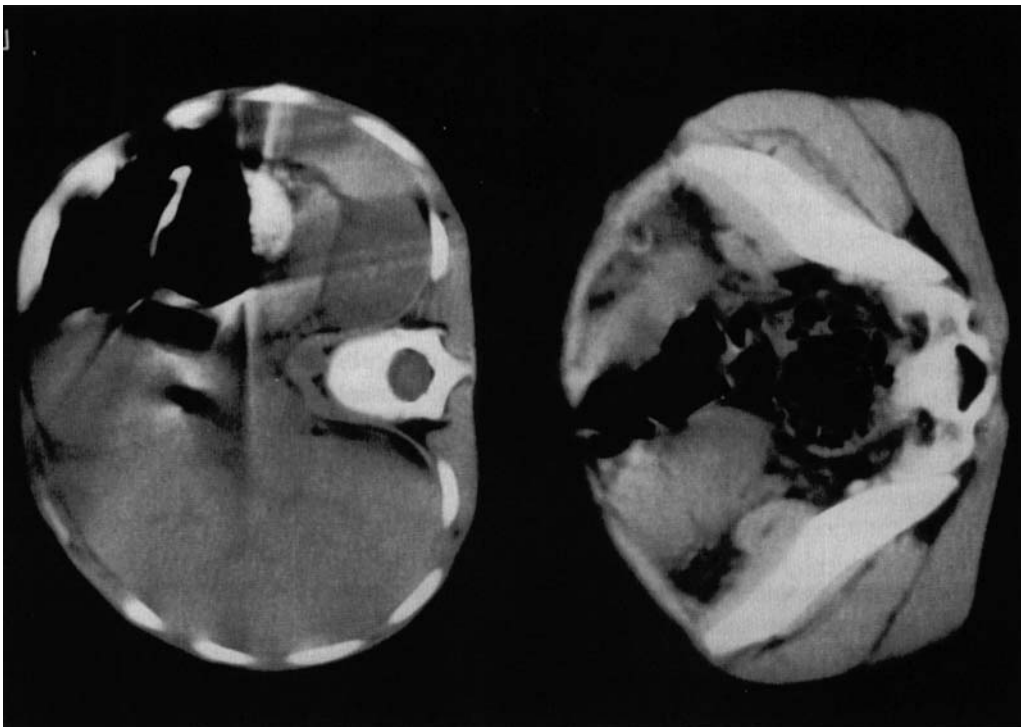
Postoperative CT: normal findings in the upper abdomen. Minimal residual pathologic tissue in the pelvis.
